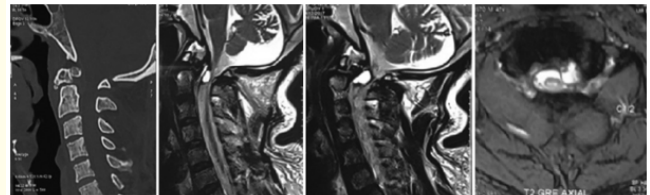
(a) Computed tomography cervical spine sagittal section showing Os odontoideum with anterolisthesis of C1 over C2 vertebrae. (b and c) Magnetic resonance imaging SAG T2 weighted image shows tectorial membrane disruption with anterolateral epidural hematoma with severe cord compression with T2 hyper intensity in posterior Atlanto occipital membrane and adjoining muscular plane suggestive of traction injury. (d) Magnetic resonance imaging T2 gradient recalled echo axial image shows compression at C1/C2 vertebral level with left anterolateral epidural hematoma.
